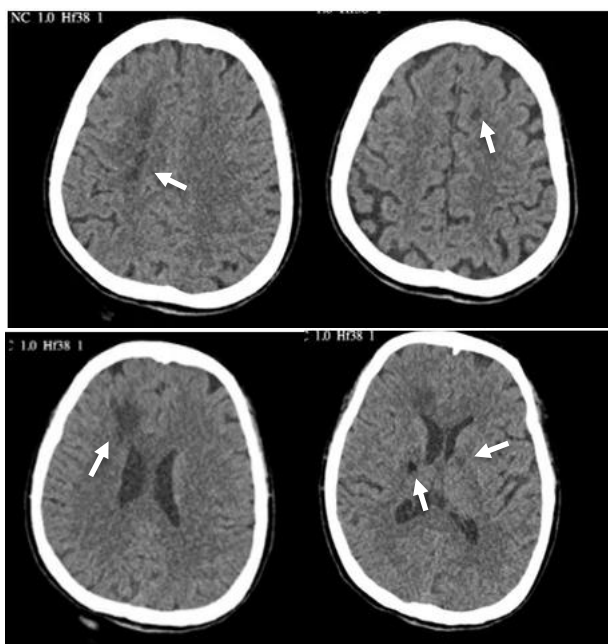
Non-contrast head CT scan showing multiple infarctions (white arrow)
